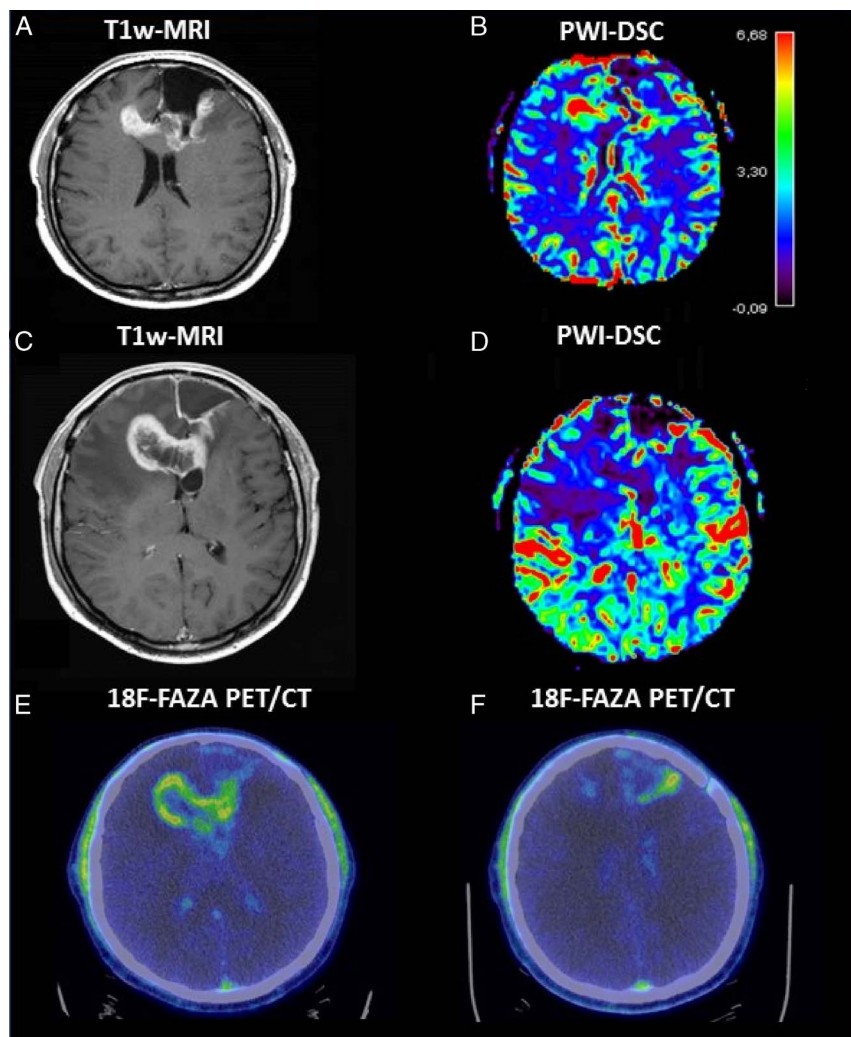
Postsurgical MRI and PWI-DSC study performed 1 month after surgery suggested progressive disease: a large enhanced area around surgical cavity and extending contralaterally (A) with CBV values showing high perfusion (B). The patient underwent adjuvant radiotherapy treatment with concomitant temozolomide, plus additional 14 monthly cycles of temozolomide. During treatment, a further brain MRI scan was performed showing a lesion enlargement as increment of edema (C) even if perfusion values (CBV, 13.72) seemed not suggestive for progression (D). As part of the aforementioned clinical protocol, a second ^{18}F -FAZA PET/CT scan was then performed for suspected recurrence. ^{18}F -FAZA PET/CT images showed increased ^{18}F -FAZA uptake in the right frontal region, suspicious for recurrence (E), with a peripheral uptake (SUV_{max} , 2.1; SUV_{mean} , 2.1; MTV_{40} , 35.60; hypoxia volume, 9.14) in correspondence of the surgical cavity (F), less intense compared with the basal scan. The patient continued the scheduled temozolomide cycles, and brain MRIs performed for treatment monitoring showed a progressive lesion reduction.
